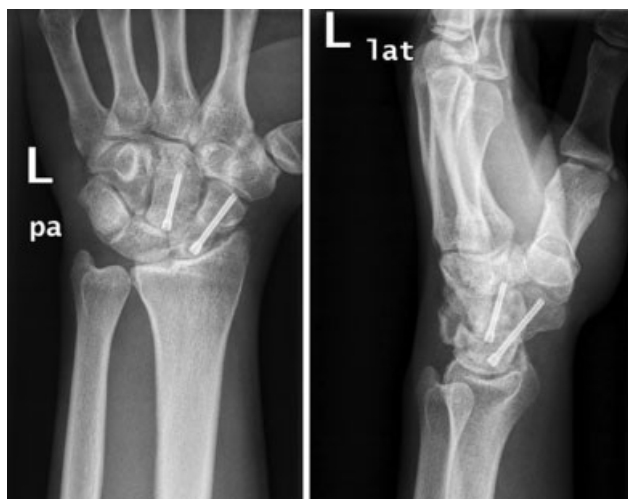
(A) Comparison between the two capitate bone fragments: the real and the three-dimensional printed bones (intraoperative image). (B) Postsurgical posteroanterior and lateral radiographs.
